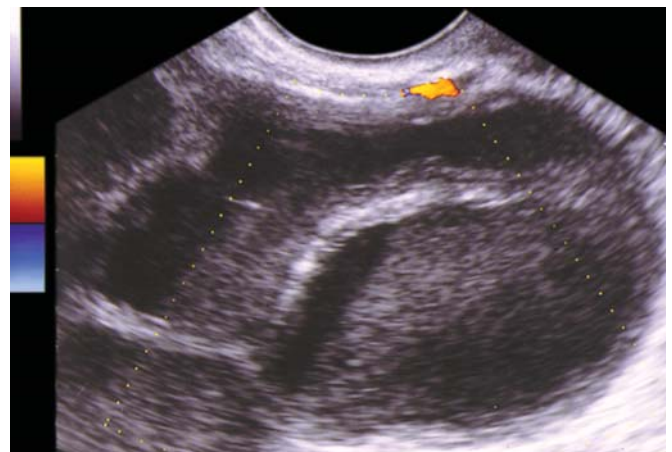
Pyosalpinx—Incomplete septa. A sonographic sign of incomplete septa is important to identify the tubal origin of the complex anexial mass. Observe the destruction of the tubal wall
